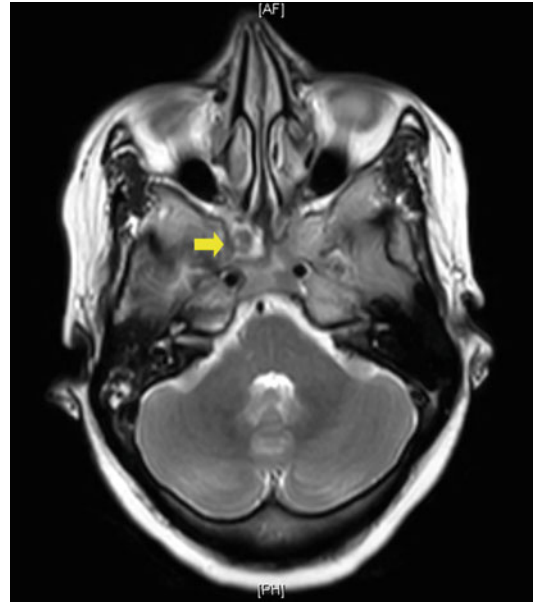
Shows an axial image of T2 MRI showing a right-side nasopharyngeal carcinoma
